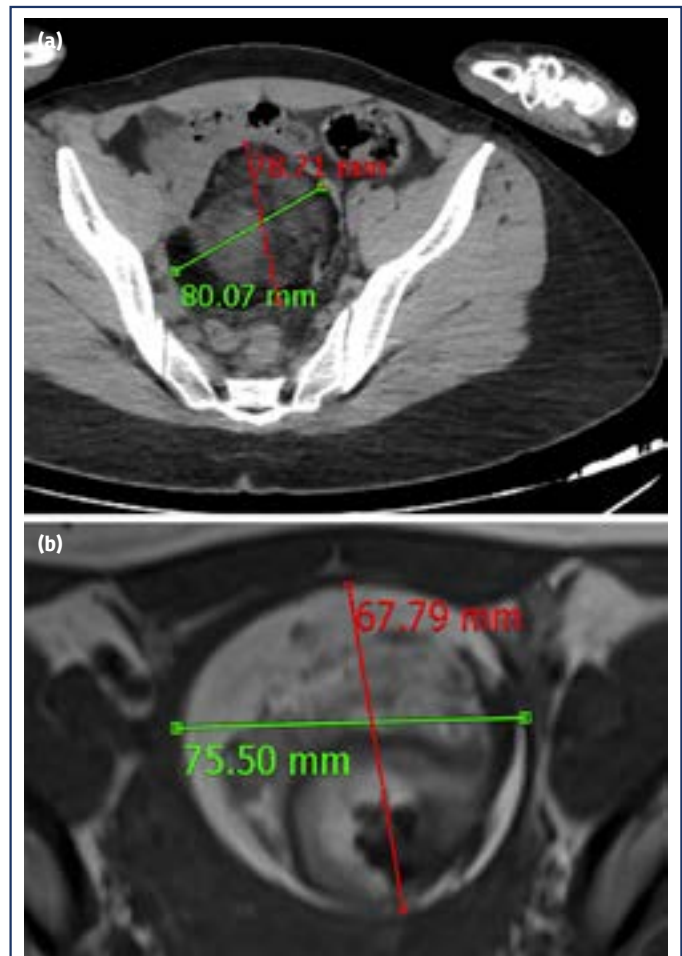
CT (a) and MR (b) images of adnexal mass
